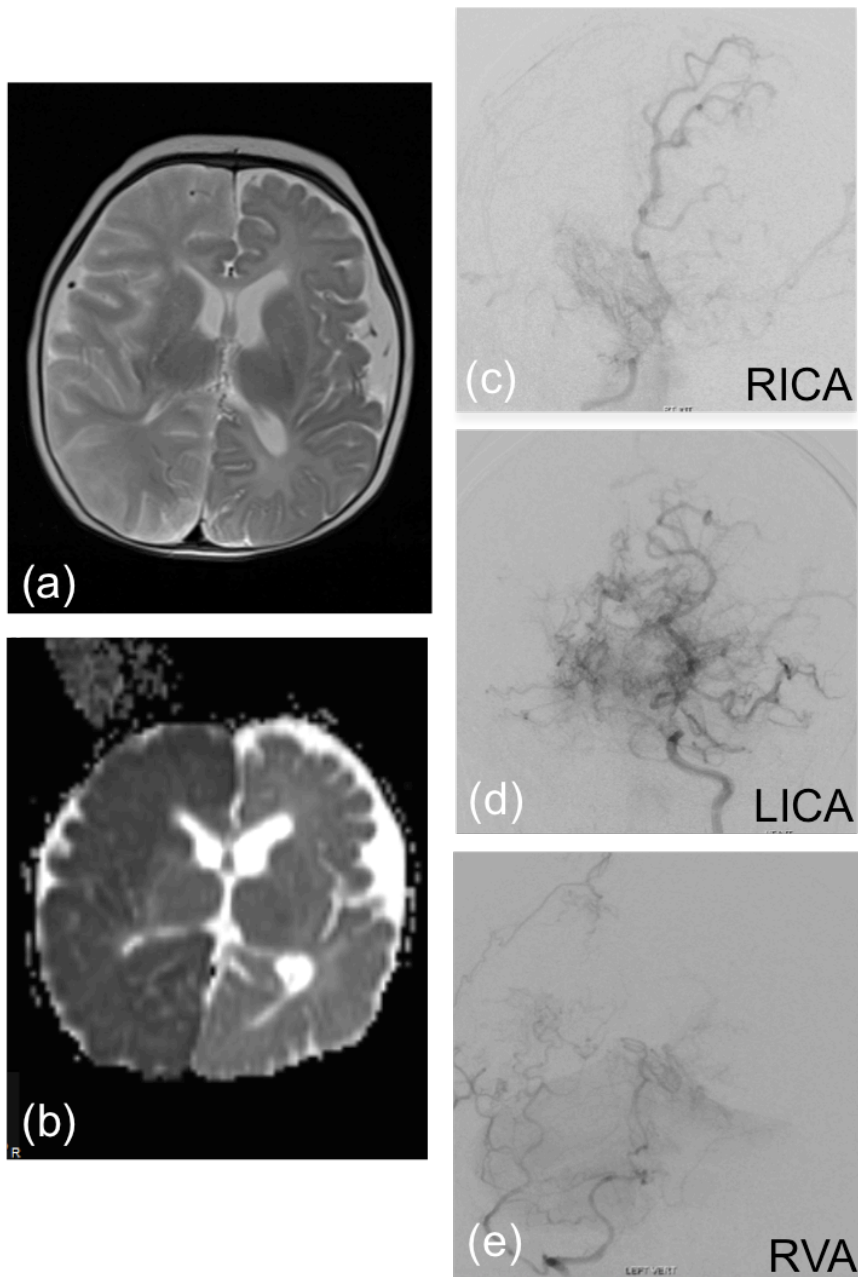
Brain MRI and catheter cerebral angiography images of the cerebral circulation for C-III-2 during initial presentation.
